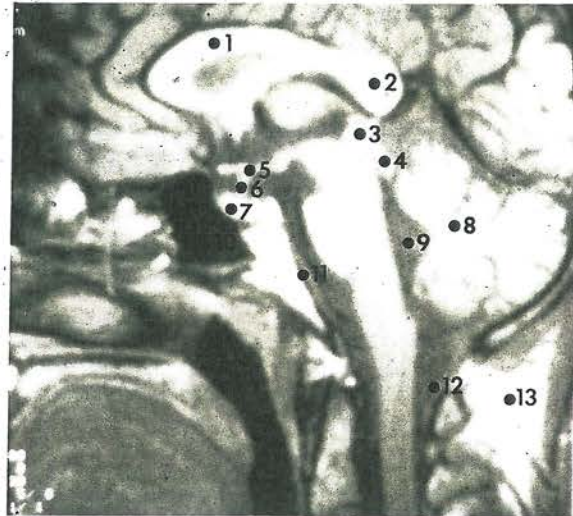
Sagittal MRI scan showing normal anatomy. 1: body of the corpus callosum; 2: splenium of the corpus callosum; 3: superior colliculus; 4: inferior colliculus; 5: infundibular recess in the floor of the third ventricle; 6: infundibulum; 7: pituitary gland; 8: cerebellum; 9: fourth ventricle; 10: sphenoid sinus; 11: clivus; 12: foramen magnum and craniocervical junction; 13: subcutaneous fat. The pineal gland is not shown clearly; it is situated supero-posterior to the colliculi
